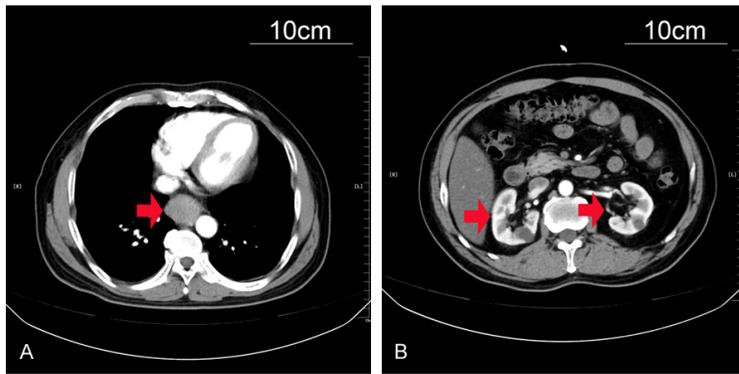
CT scan images of primary esophagus tumor and normal kidney before esophagectomy. Sixty four-slice CT scan image of primary tumor of esophagus (A) and normal kidney (B) before esophagectomy.
